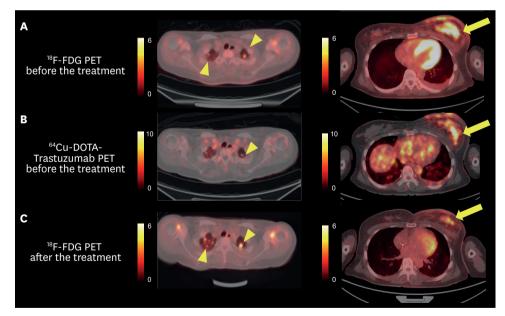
18F-FDG PET/CT and 64Cu-DOTA-trastuzumab PET/CT images before and after the treatment. Before the treatment, the uptake of ¹⁸F-FDG was definitely observed at the lesions of lung metastases (arrowheads, left side of panel A), whereas the uptake of 64Cu-DOTA-trastuzumab at the same lung lesions was not clear (arrowheads, left side of panel B). The uptake of both ¹⁸F-FDG (right side of panel A) and ⁶⁴Cu-DOTA-trastuzumab (right side of panel A) were definitely observed at the recurrent lesions of the left breast (arrows). After the treatment, the size and metabolic activity of a few metastatic lung lesions increased (arrowheads, left side of panel C). The SUV_{max} of the left upper lung lesions increased from 3.2 (left side of panel A) to 5.6 (left side of panel C). However, the extent and metabolic activity of the recurrent lesions in the left breast decreased (arrows, right side of panels A and C). The SUV_{max} of the recurrent lesion in the left breast decreased from 12.0 (right side of A) to 6.4 (right side of panel C). ⁶⁴Cu-DOTA-trastuzumab PET image was obtained 48 hours after the ⁶⁴Cu-DOTA-trastuzumab injection. FDG = fluorodeoxyglucose; PET = positron emission tomography; CT = computed tomography; DOTA = tetraazacyclododecanetetra-acetic acid; SUV_{max} = maximum standardized uptake value.
